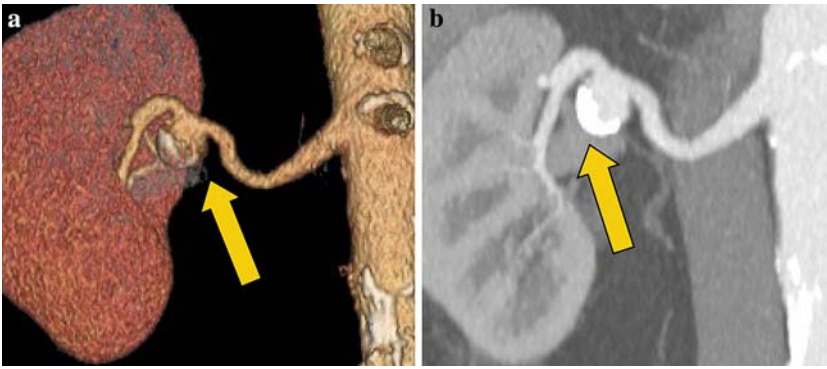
Renal artery aneurysm. Volume rendered CTA (A) and maximum intensity projection CTA (B) of the right renal artery demonstrates a 1.5 cm partially calcified aneurysm arising from the distal main right renal artery inferiorly.
